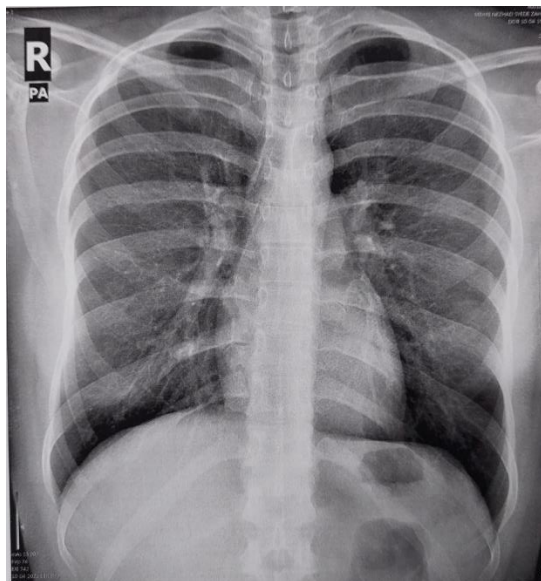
Chest X-ray of the patient with no significant findings
